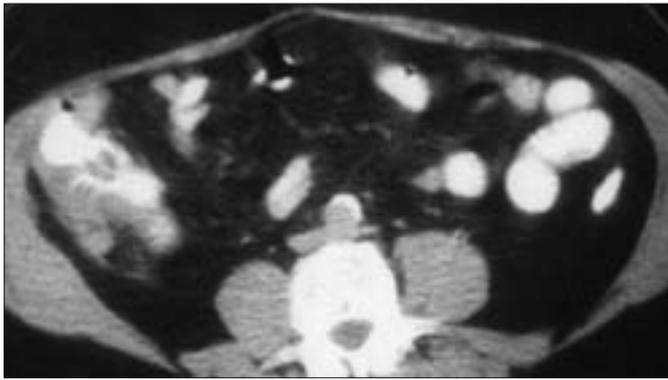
Axial CT image shows the inflammatory changes thickening the cecal wall and involving the peri-cecal fat due to appendicitis.
